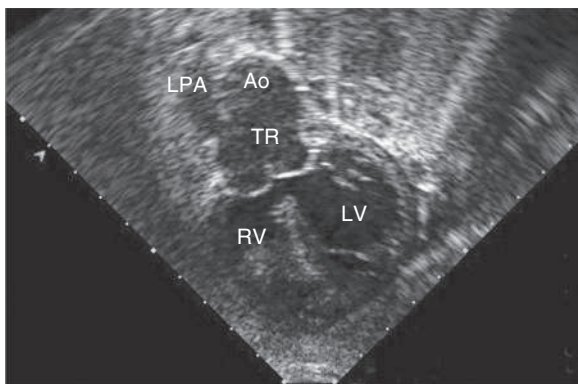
Subcostal 2D echocardiographic demonstration of truncus arteriosus. The large truncal valve can be seen overriding the ventricular septal defect. In this case, only the left pulmonary artery (LPA) arises from the truncus (TR). The pulmonary arteries are discontinuous, and the right pulmonary artery arises from the descending aorta via the ductus arteriosus (not shown). Ao, Aorta; LV, left ventricle; RV, right ventricle.
